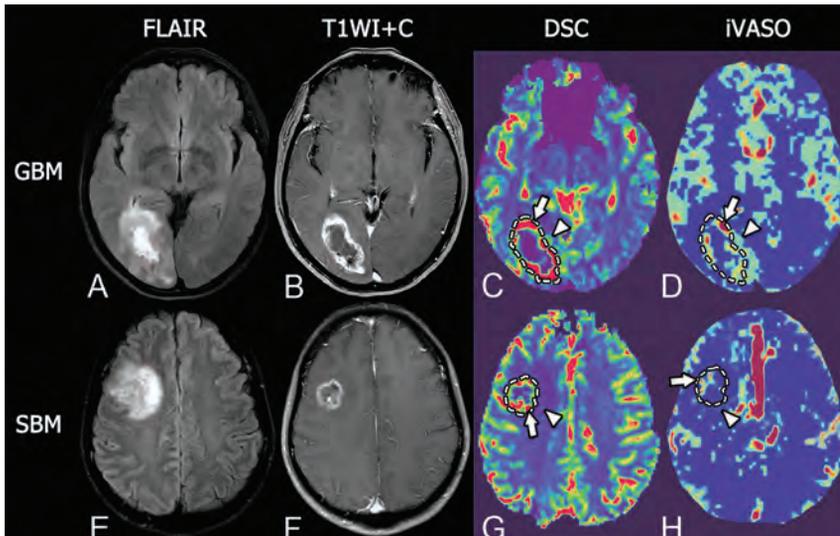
Representative MR images of glioblastoma and single brain metastasis. *Upper row, A* GBM in a 51-year-old woman. *Lower row, E* SBM in a 46-year-old man. Both GBM and SBM present as hyperintense masses on T2 FLAIR with extensive peritumoral edema (A and E) and show a ring-enhancement pattern on fat-suppressed postcontrast T1WI with prominent necrosis in the tumor center (B and F). In intratumoral regions, GBM shows maximum DSC-rCBV similar to that of SBM (5.29 versus 4.98, arrows in C and G), but higher maximum iVASO-CBVa than SBM (5.90/100 mL versus 1.30/100 mL, arrows in D and H). In the peritumoral region, GBM shows prominently higher DSC-rCBV and iVASO-CBVa than SBM (DSC-rCBV, 3.11 versus 1.25, arrowheads in C and G; iVASO-CBVa, 1.20/100 mL versus 0.55/100 mL, arrowheads in D and H).
